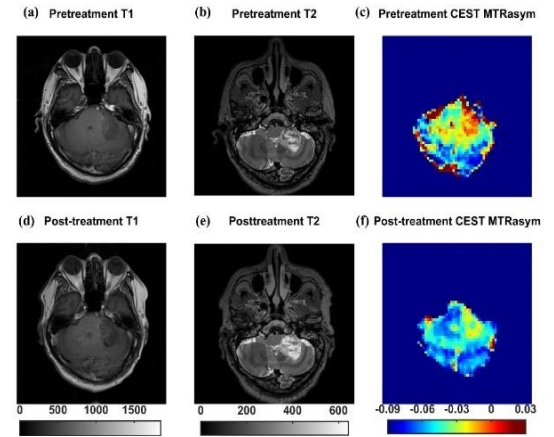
Representative brain MRI images from Patient 1. Pre- and post-treatment of (a,d) T₁-weighted imaging, (b,e) T₂-weighted imaging, and (c,f) CEST MTR_{asym} (3.5 ppm).
